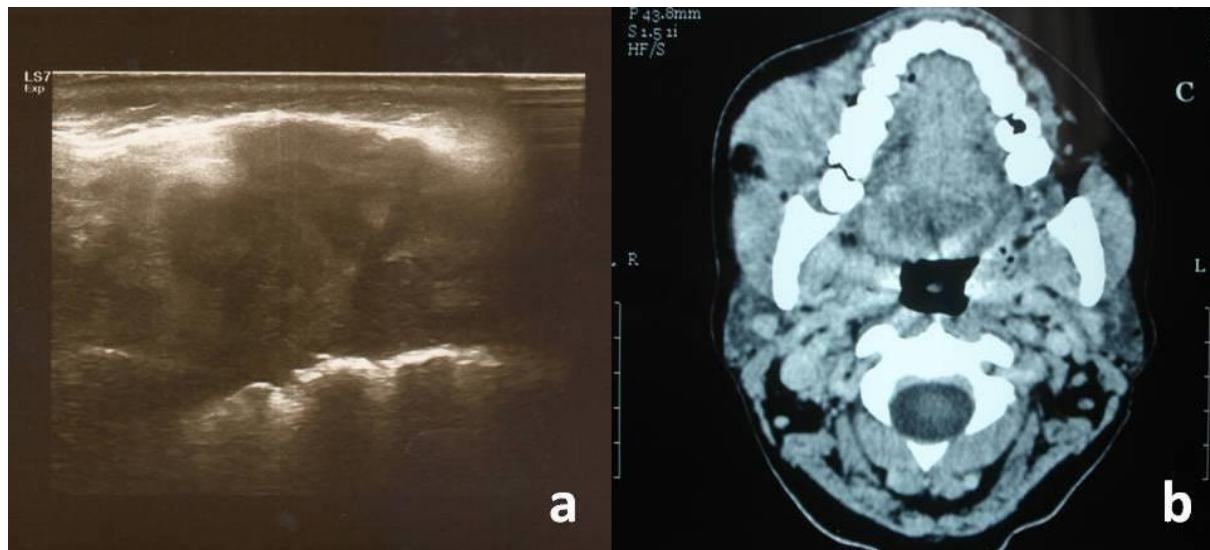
Ultrasonographic (a) and computed tomographic image (b) of the lesion in the right cheek.
